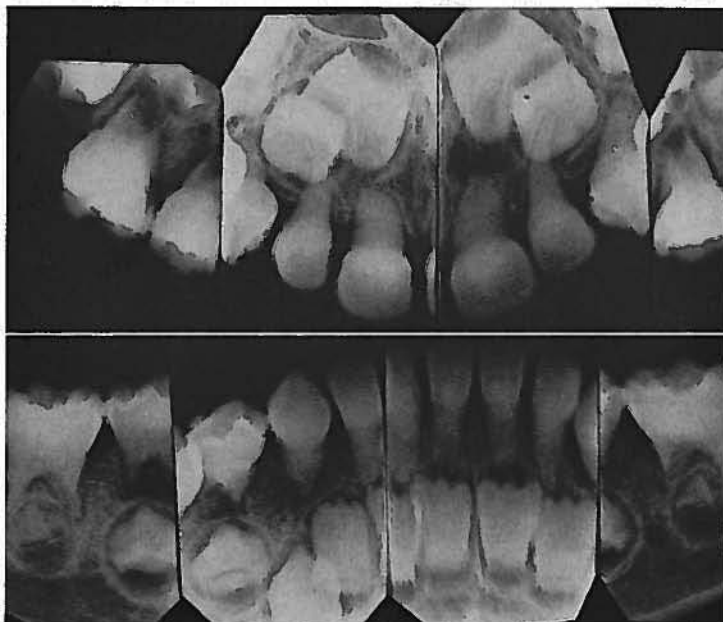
Roentgenograms showing the affected deciduous dentition and even the unerupted permanent teeth of one grandson. Malformed roots and obliterated pulp chambers and canals are evident.
